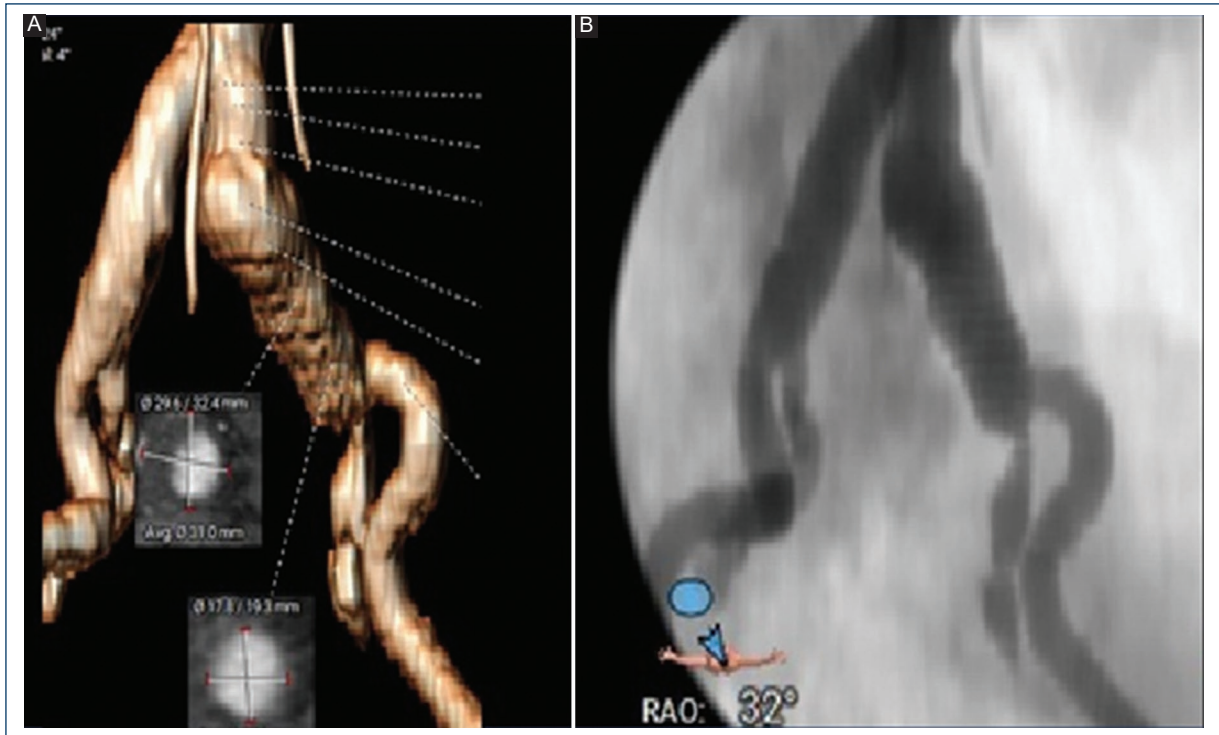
A: 3D CT angiography and arteriography showing left common iliac artery aneurysm. B: neck of 13 mm, largest diameter of the aneurysm of 36 mm and distal neck of 10.6 mm.
